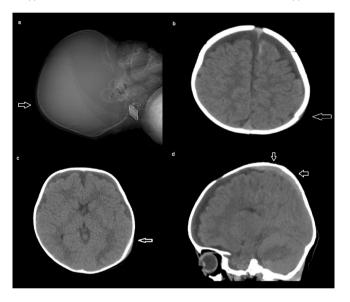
Linear fracture of parietal zone on x-ray(a). Left parietal linear fracture on initial CT (b). Epidural hemorrhage under fracture as a thin layer on control CT (c). Parietal epidural hematoma on sagittal section (d)
